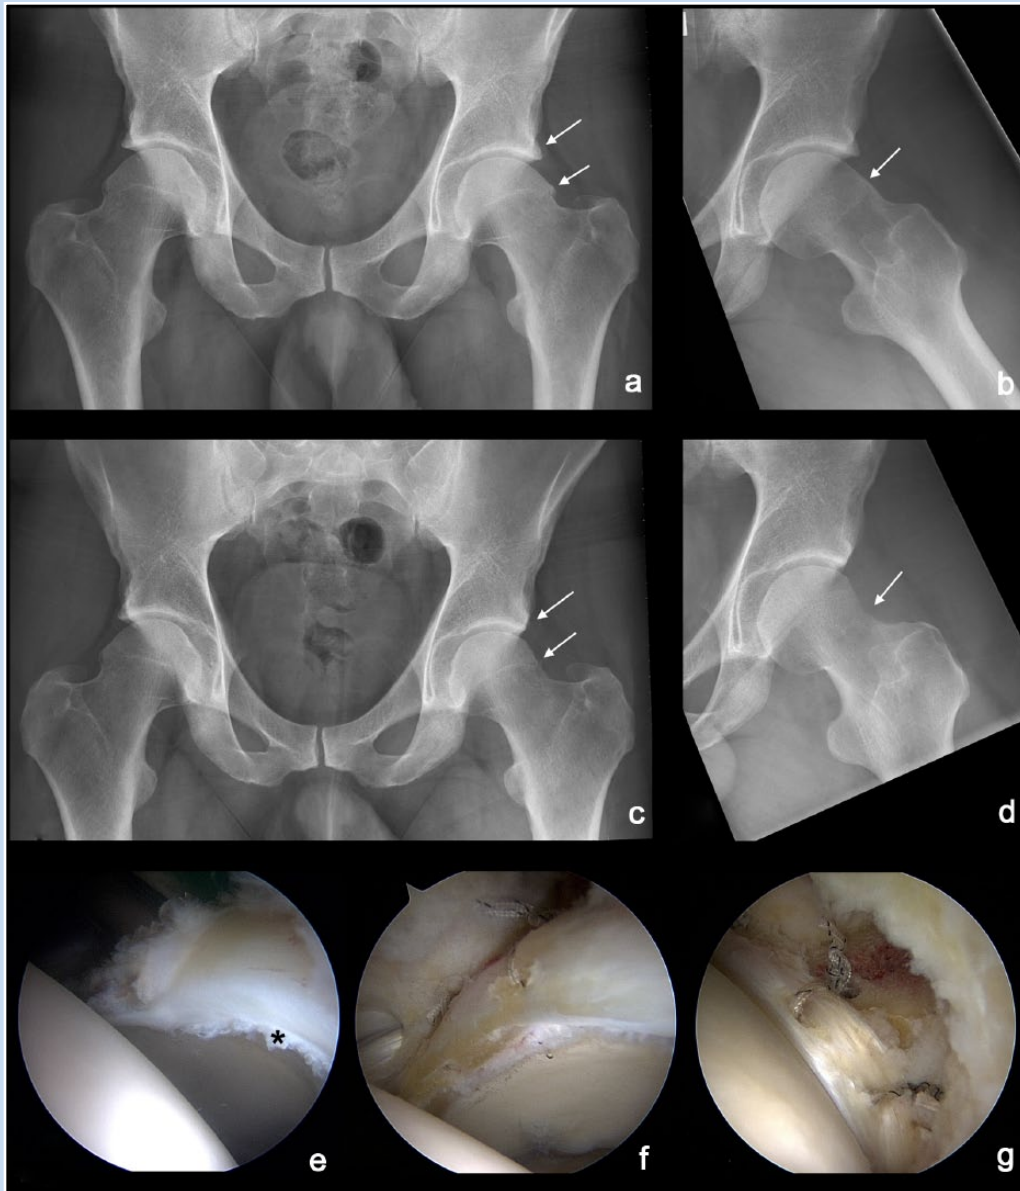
Left hip combined femoroacetabular impingement with labral tear. (a and b) Preoperative anteroposterior and Dunn lateral radiograph demonstrating the combined cam- and pincer-type pathomorphology (arrows). (c and d) Postoperative radiographs demonstrate correction of the acetabular overcoverage and restoration of the femoral head-neck offset (arrows). (e) Intraoperative view of the acetabular labral tear (*). (f and g) Labral repair with base-type configuration and restoration of the labral suction-seal.
